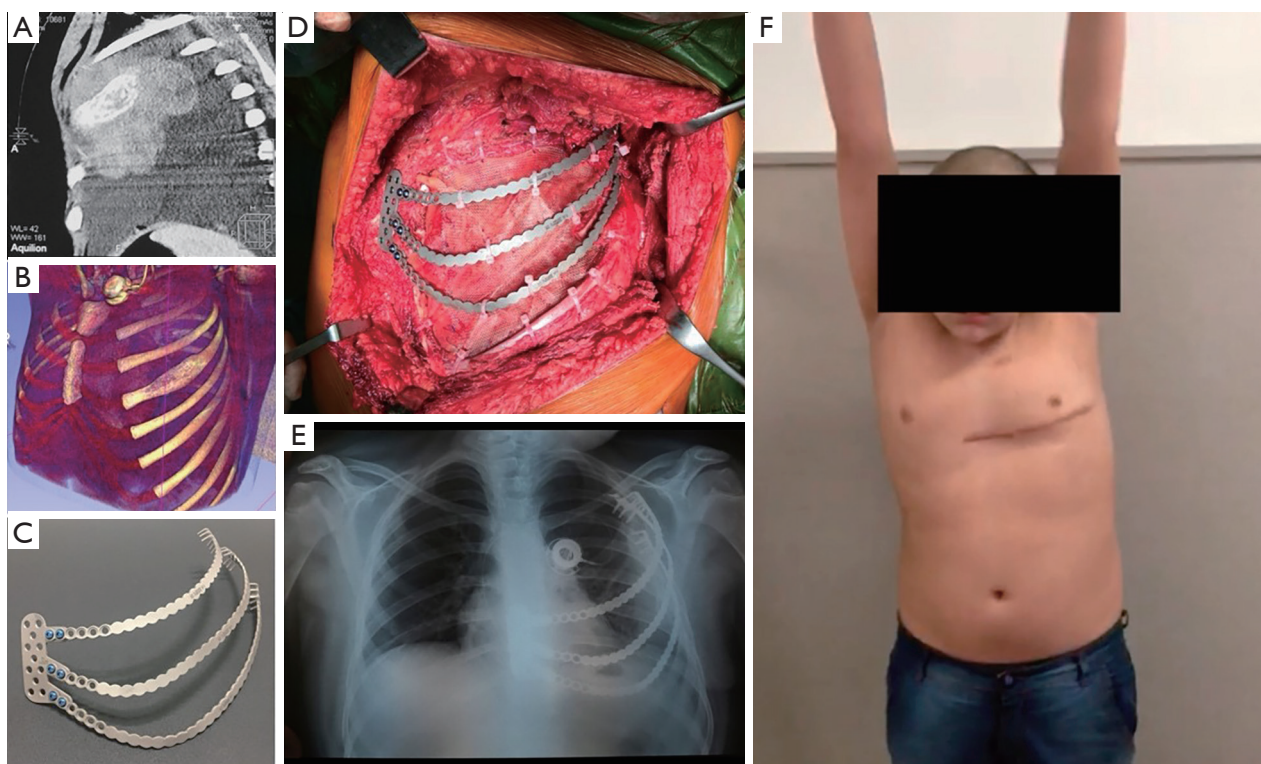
Preoperative planning, implant customization, surgery, and postoperative results of a pediatric patient with an Ewing sarcoma of his 4th left rib requiring a wide chest wall resection. (A) Chest CT scan showing rib involvement by the tumor. (B) 3D CT reconstruction where the extension of the tumor can be easily comprehended. (C) Customized, titanium sterno-costal prosthesis comprised of a sternal plate and three separate ribs. (D) Intraoperative view of the prosthesis already fixated after wide chest wall resection, covering a non-absorbable mesh. (E) Front chest X-ray, showing the metallic implants, good lung expansion, and a port-a-cath. (F) The patient at the 1-month postoperative visit to the outpatient clinic. He is moving his arms freely and his chest is symmetric. CT, computed tomography; 3D, three-dimensional.
